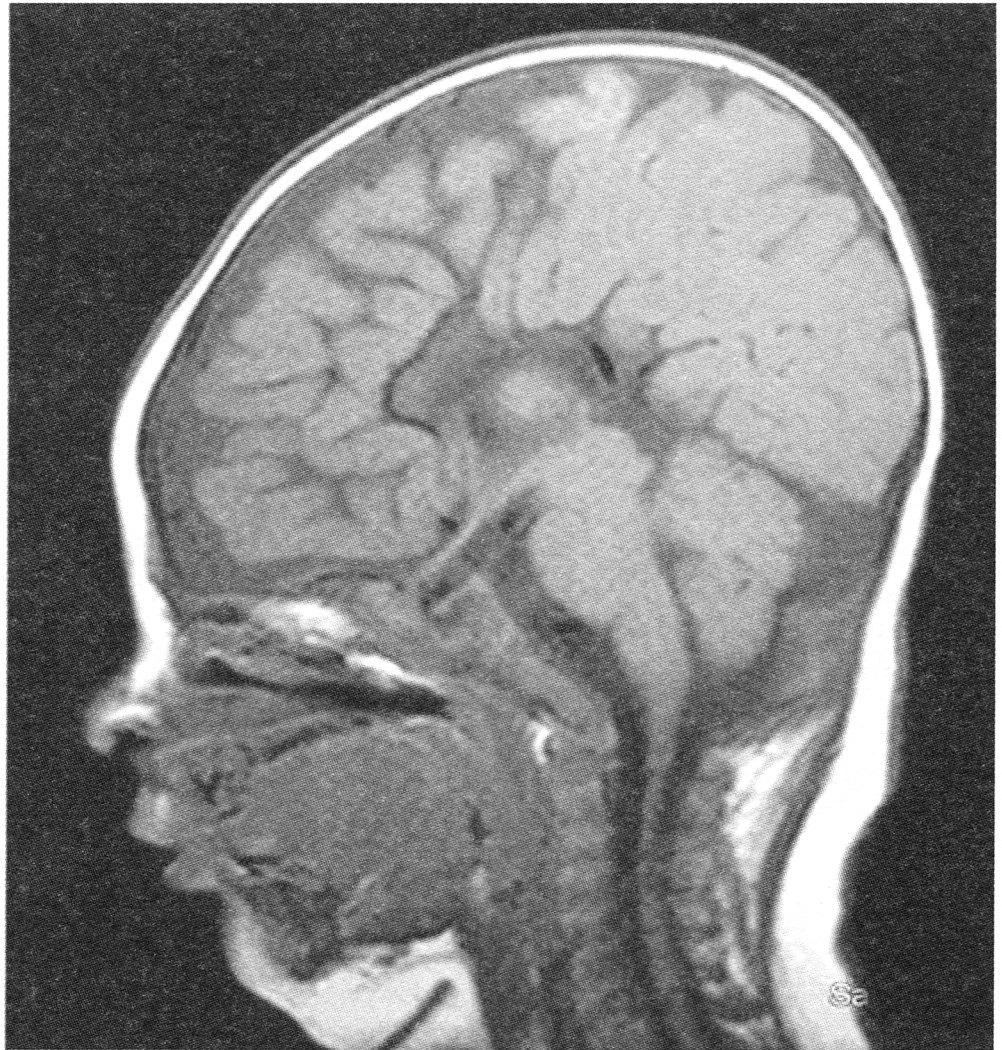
Saggital brain CT of the patient showed agenesis of corpus callosum.
